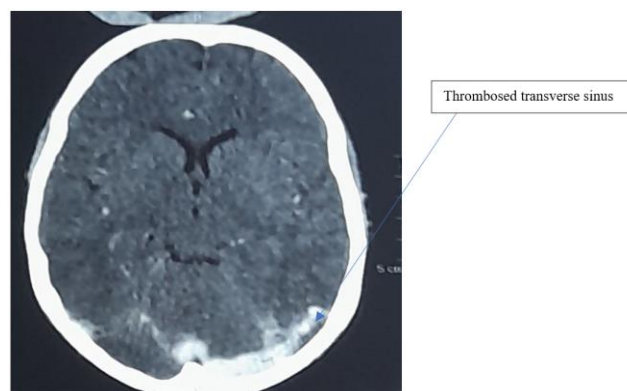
Axial CT brain section: transverse sinus thrombosis.
